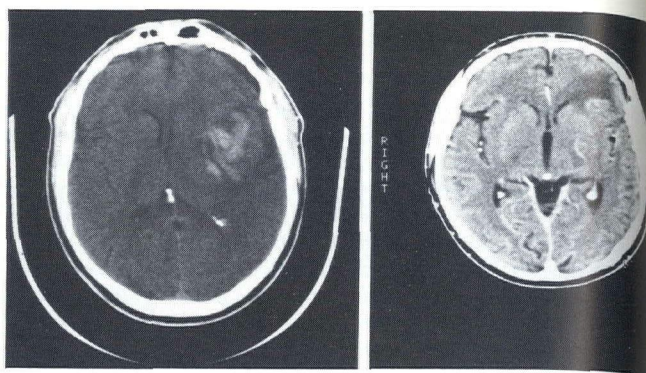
Case 1: Presurgical (left panel) and four months postsurgical (right panel) computed tomography scans.
